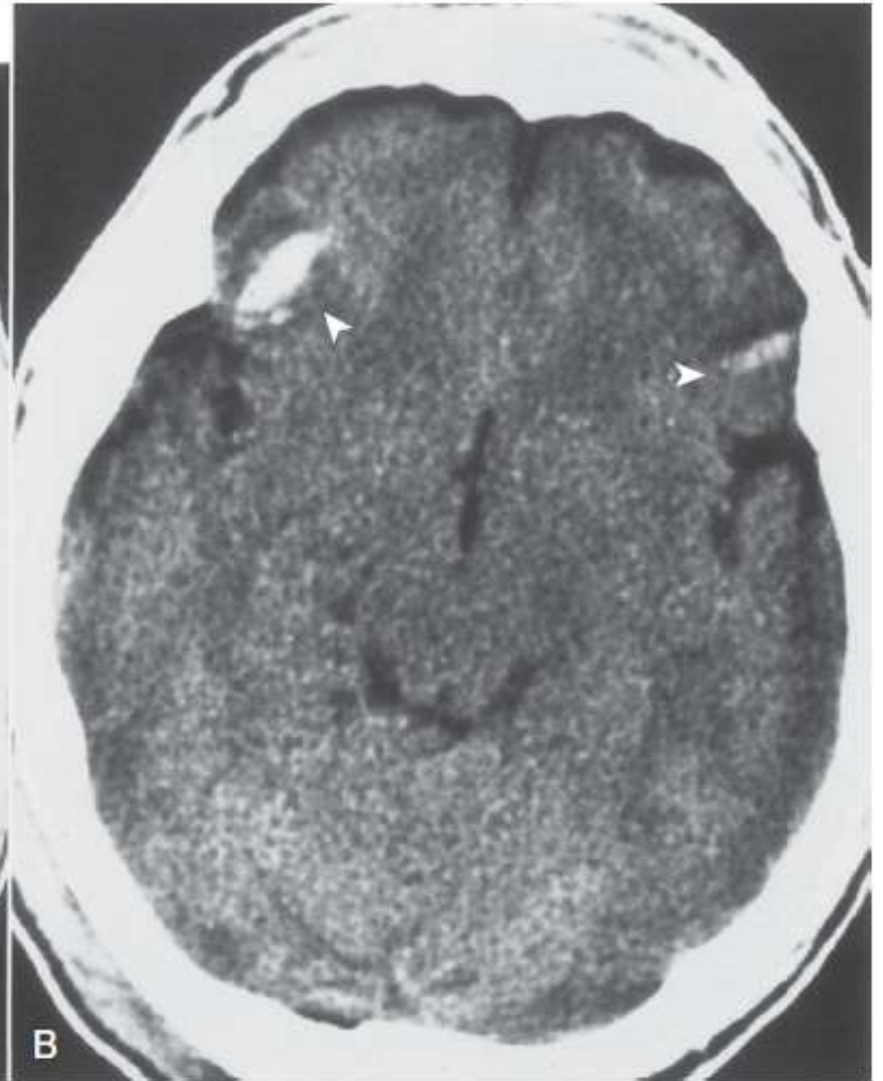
A, Hemorrhagic contusions with surrounding edema are evident in the inferior left frontal and anterior right temporal lobe (*arrowheads*). B, CT scan at higher level reveals additional cortical hemorrhagic contusions in the frontal lobe (*arrowheads*).
